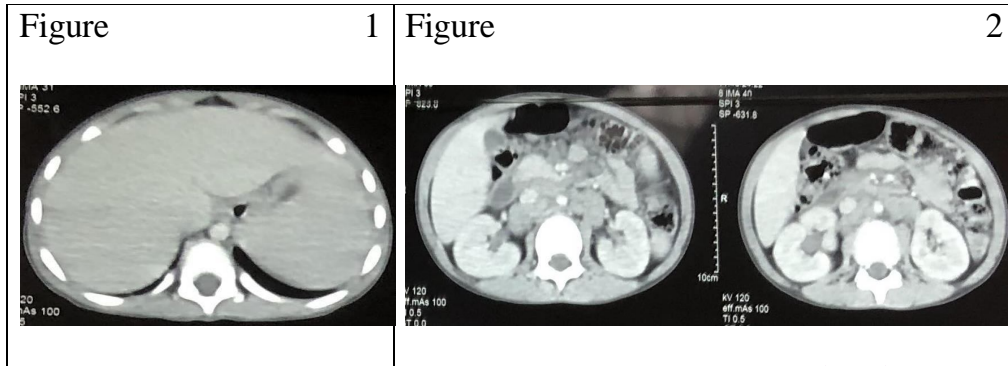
The cervico-thoraco-abdominal CT scan (CT) OU CERVICO-THORACO-ABDOMINAL SCAN (CT)
